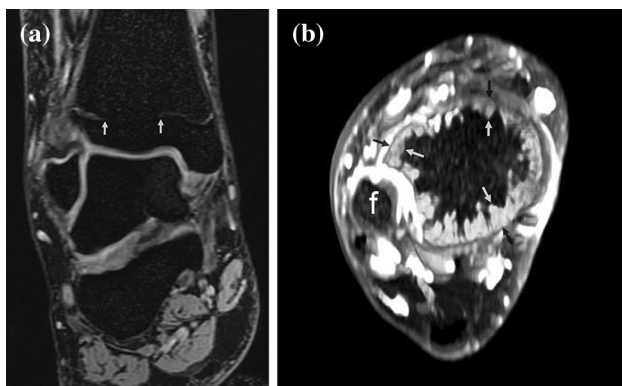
Three-dimensional high-resolution T2-weighted MRI (a) showing the formation of a bone bar. The bright signal intensity of physal cartilage ends (arrows) at the bone bar in the central portion of the tibial physis. The maximum intensity projection image of this 3D dataset (b) shows the residual rim of physal cartilage at the periphery of the tibia (arrows) and extent of the bone bar (black in center of tibia). The map helps guide decisions. This map shows a large bone bar that was treated conservatively. The map of small lesions helps guide surgery. *f* fibula
